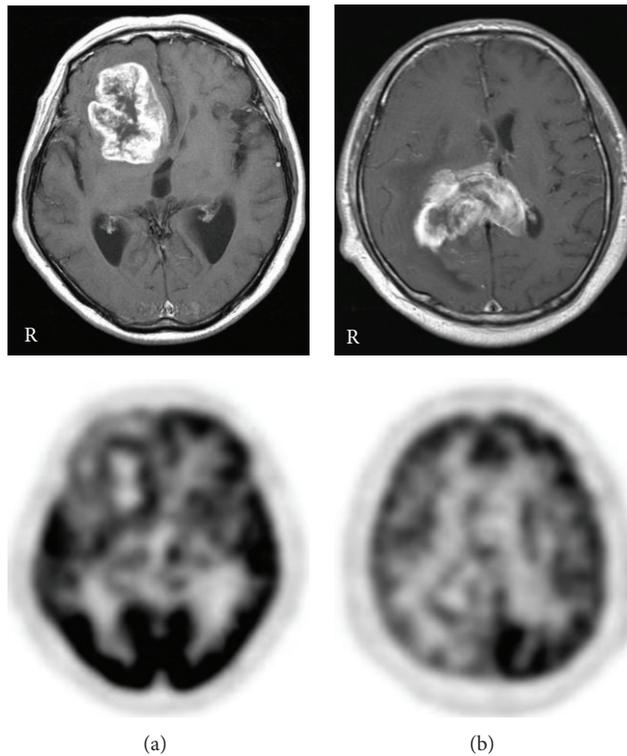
Contrast-enhanced T1-weighted MR (upper) and <sup>18</sup>F-FDG PET (lower) images in GB patients. MR images show a heterogeneous ring-like enhanced lesion in the right frontal lobe (a) and the splenium (b). PET images show a mild ring-like <sup>18</sup>F-FDG uptake in the lesions.
